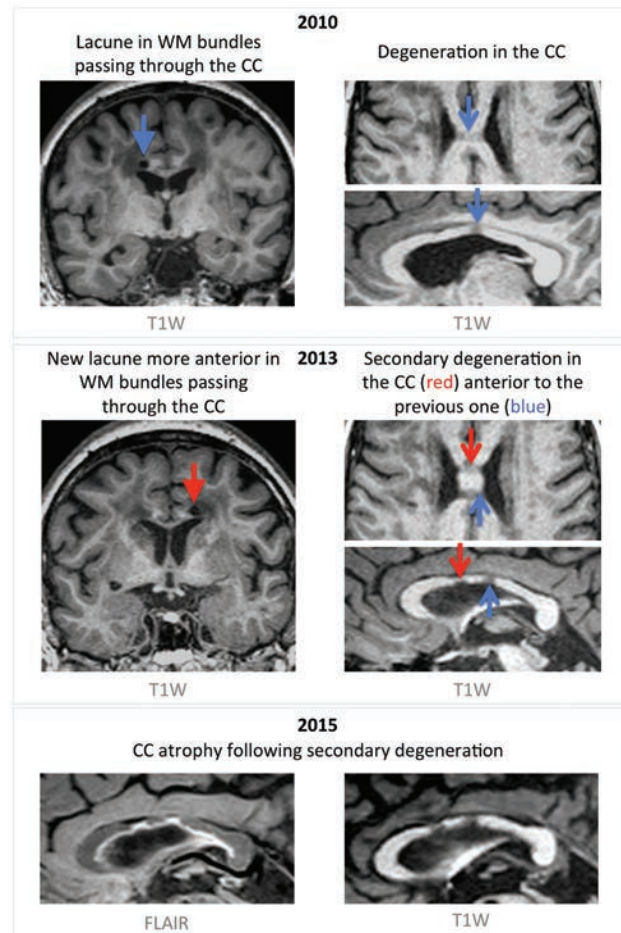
Corpus callosum atrophy through the appearance of lacunes and secondary white matter degeneration. An example of a 56-year-old patient with CADASIL presenting in 2010 with hypointense T1-weighted signal in the corpus callosum (CC), presumably as a consequence of a lacune located in white matter bundles passing through the CC body (*top panel*). In 2013, a new lacune occurred in bundles passing through the CC, localized anterior to the previous one and leading to another hypointense area in the CC (*middle panel*). Images acquired in 2015 show progressive CC atrophy due to degeneration secondary to the appearance of lacunes (*bottom panel*). T1W indicates T1-weighted.
